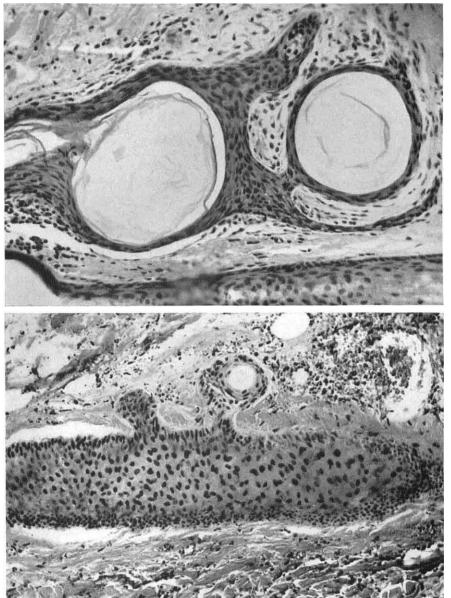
a. Milium and epithelial bud arising from the external root sheath in an experimental autotransplant. b. Milia occurring in the dedifferentiated cellular column of the hair matrix after x-ray epilation.
